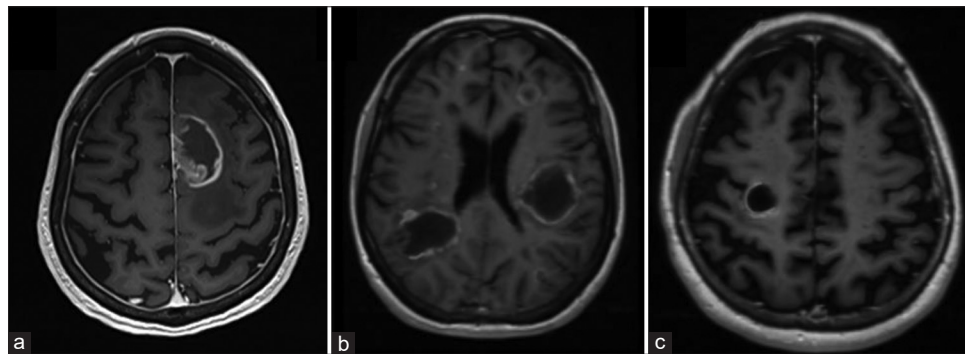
(a) Post contrast axial T1 MRI demonstrates irregular closed enhancement of a left frontal high-grade glioma with mild mass effect characterized by sulcal effacement without midline shift. (b) Post contrast axial T1 MRI demonstrates multiple lesions with the right parietal lesion demonstrating open rim enhancement. All lesions demonstrating no mass effect. (c) Post contrast axial T1 MRI demonstrates regular open enhancement of a right frontal TDL with no mass effect or edema.
